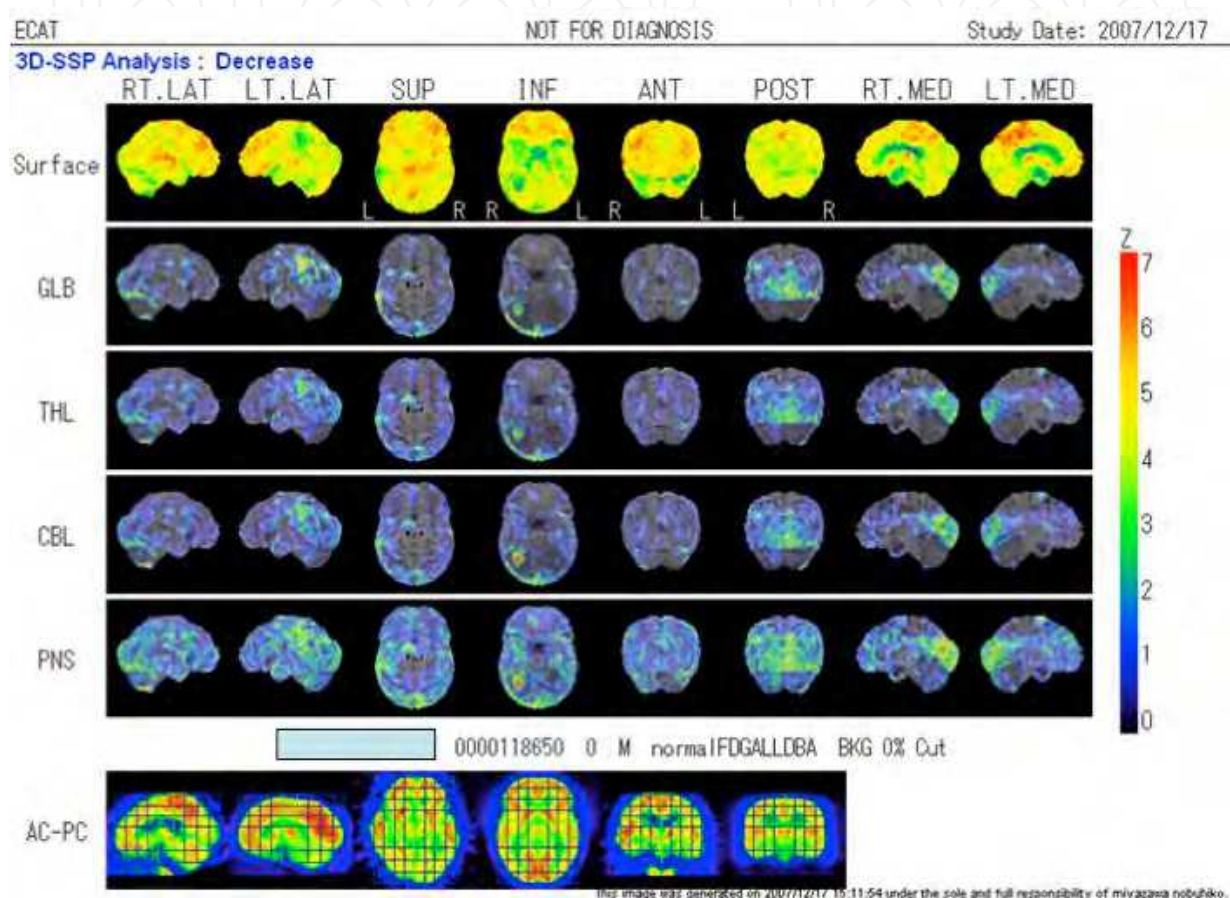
FDG-PET study of DLB. Hypometabolism in the bilateral occipital lobes and posterior cingulate cortices is clearly detected by Z-score mapping with 3D-SSP.
